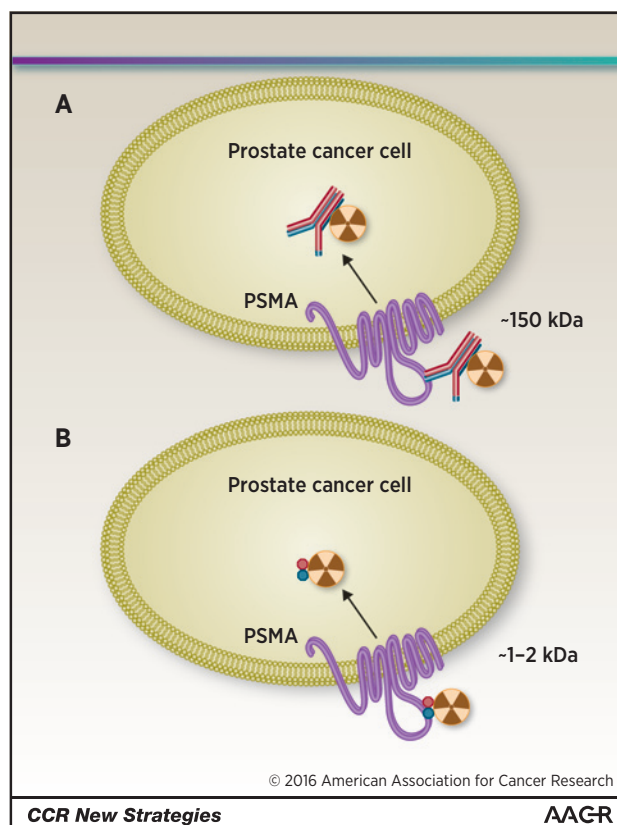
After binding to PSMA, the ligand (A, antibody; B, small molecule) is internalized into the cell. Because the clearance of small molecules is very fast, this leads to an excellent contrast during the first 60 minutes after injection of the molecule.
